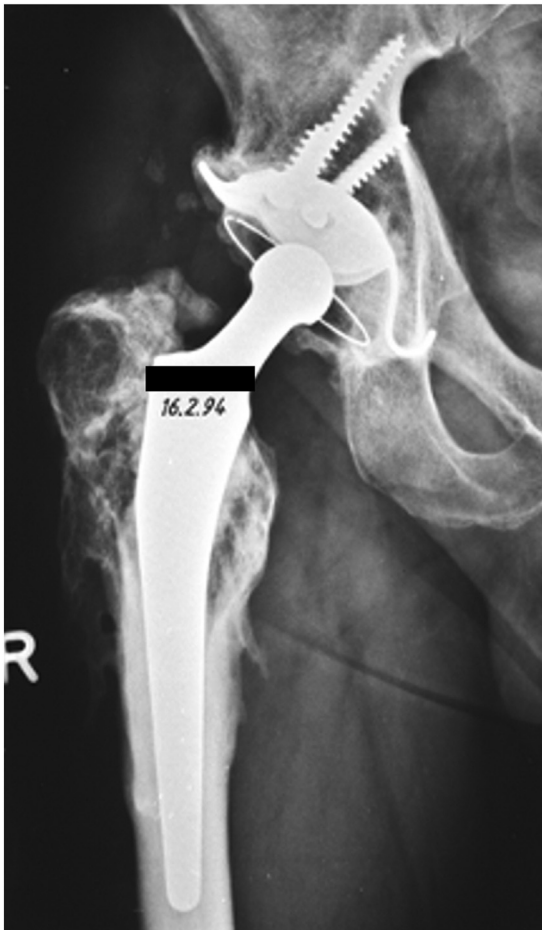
Five-year postoperative anteroposterior radiograph, demonstrating a solidly fixed total hip arthroplasty with no loosening.
